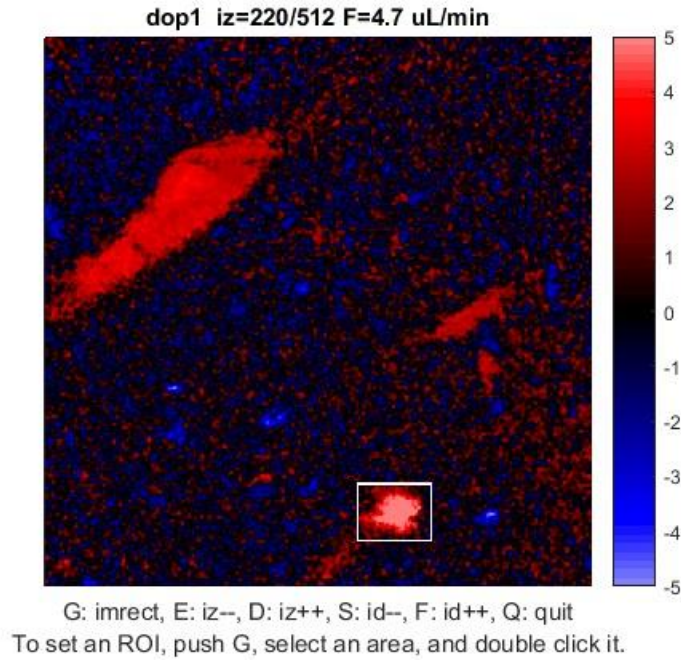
An example of Doppler OCT map of the flow velocity (experiment ID: 180328). This image shows blood flow at a z depth of 220 pixels (equivalent to 770 μm from the cortical surface). F gives the volumetric blood flow in $\mu\text{L}/\text{min}$. The color bar represents the range of velocities in mm/s . Arteries are shown in red (flowing into the cortex), and veins are shown in blue (flowing out of the cortex).
